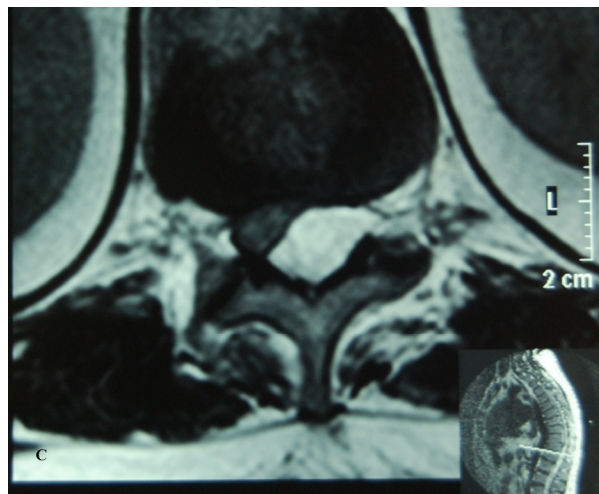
Axial T1W MRI image showing a hyperintense lesion in the posterior epidural space displacing the cord anteriorly and compressing it
